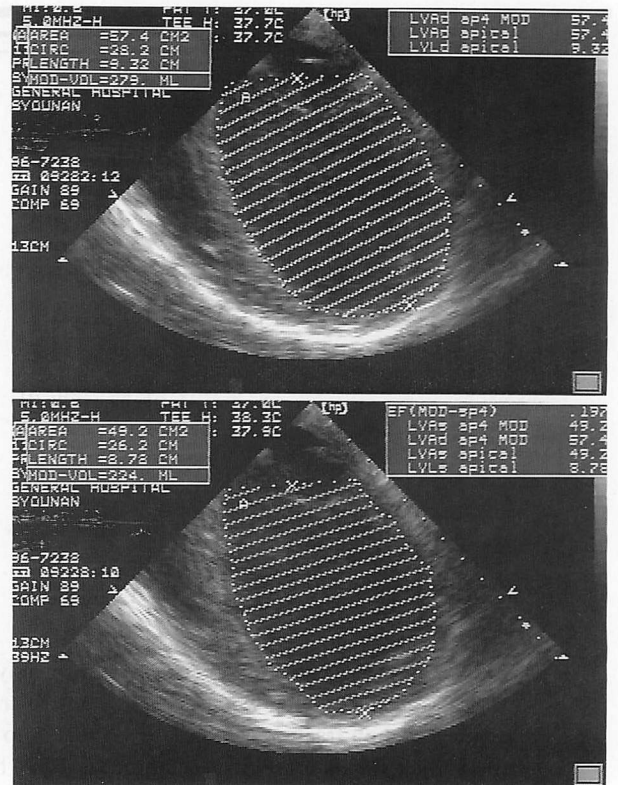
Preoperative echocardiograms
